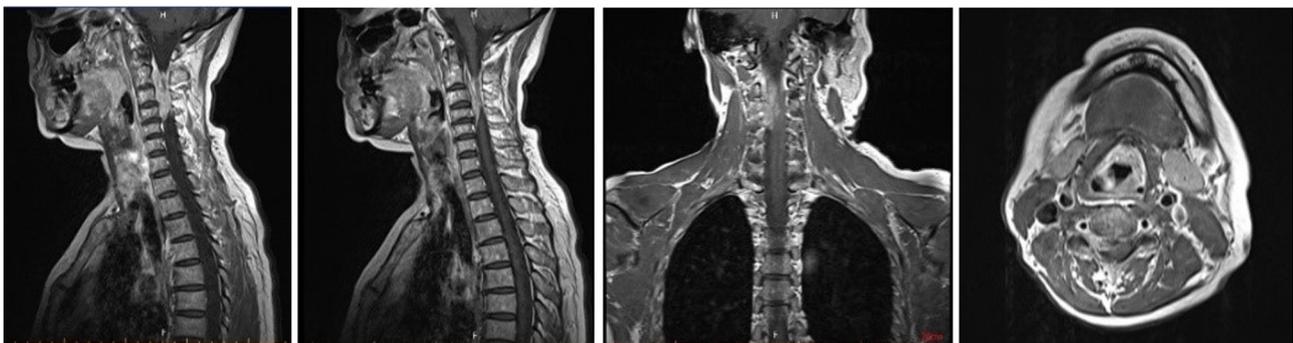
Cervical spine enhanced magnetic resonance imaging 3 days after initial admission.
